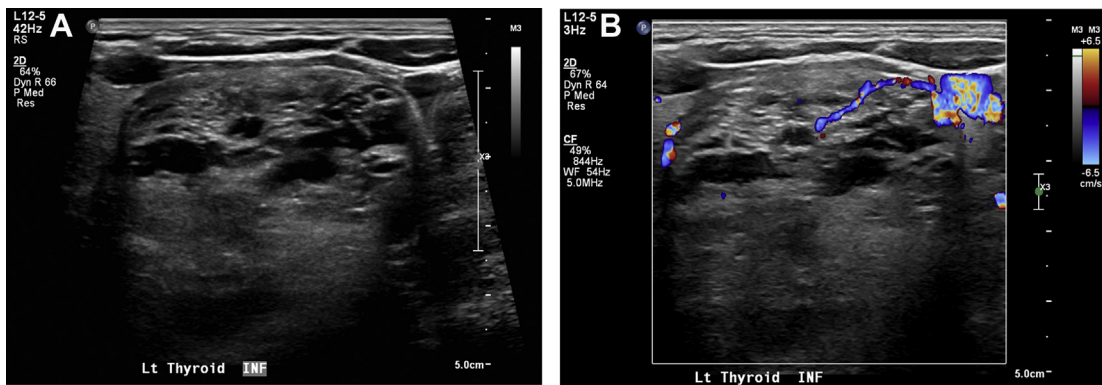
Grayscale (A) US image shows a benign spongiform pattern, considered Very Low Suspicion under ATA and TR1 Benign under ACR TI-RADS. On color Doppler (B), there is no abnormal vascularity within the nodule.
